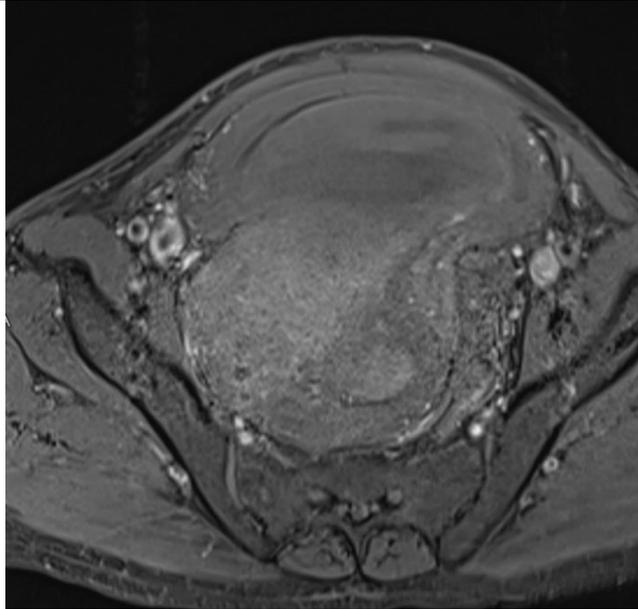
a) Abdominopelvic MRI: T1 axial after contrast injection
